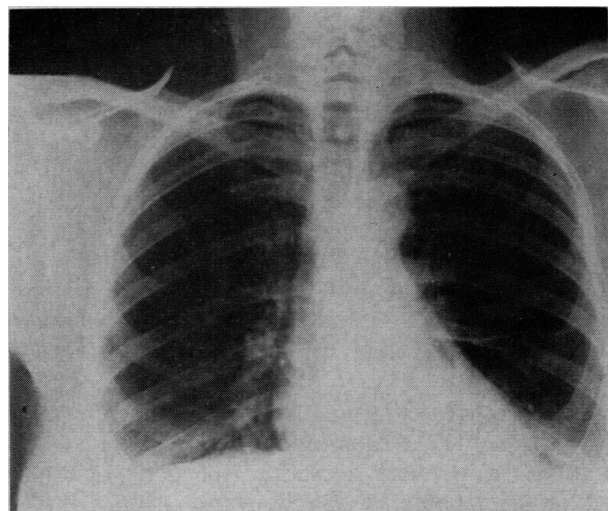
Follow-up chest radiograph three years after resection shows only minimal residual pleural thickening at the left base.
